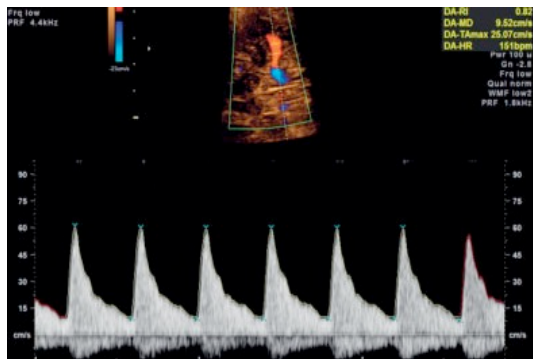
An acceptable Middle Cerebral artery Doppler shift waveform with an angle of insonation near 0°.(360)
